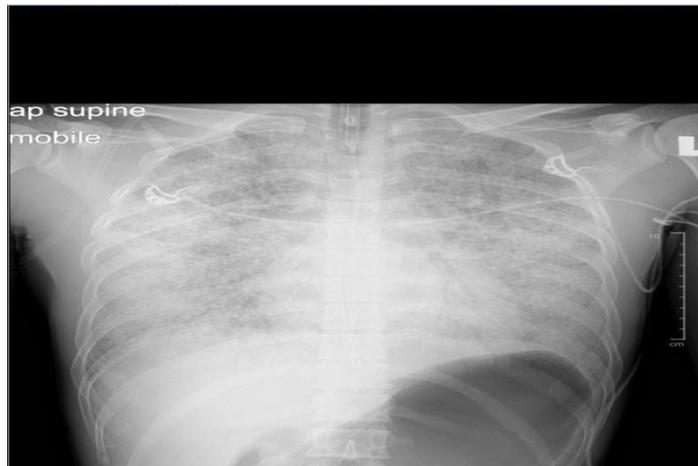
Chest X-Ray during treatment on 6th Jan 2019 (Before ECMO)
